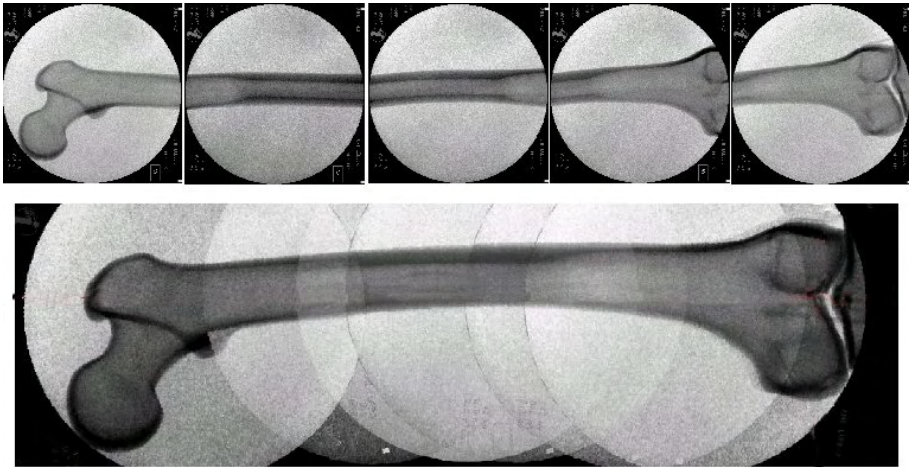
Radiographs and combined longbone-panorama from real experiments with the C-arm.
